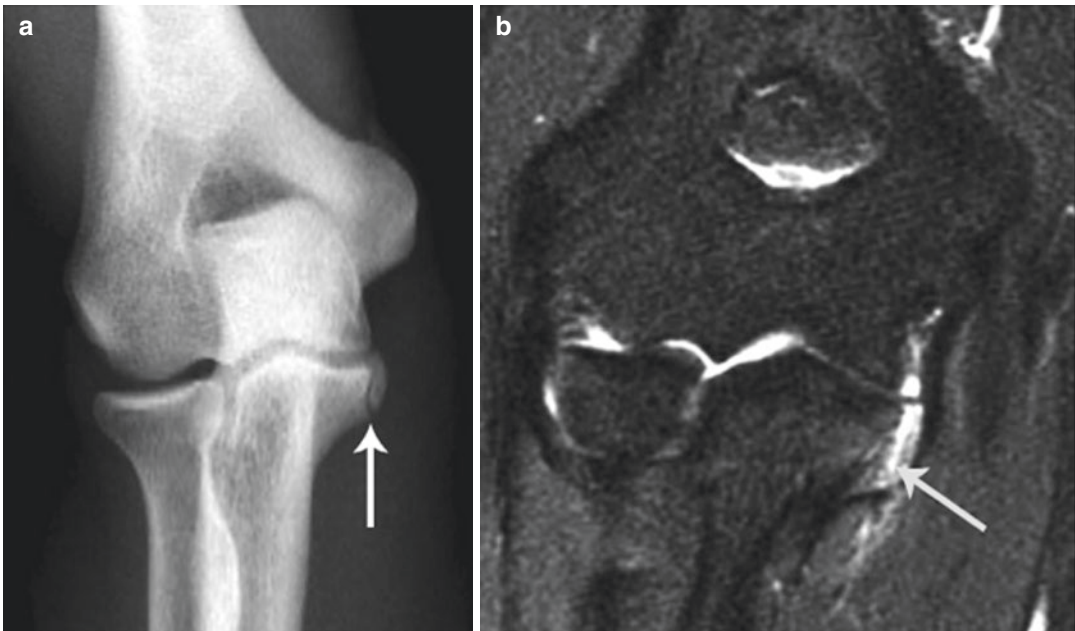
Plain film (a) and coronal STIR (b) demonstrate avulsion injury of the sublime tubercle (*arrows*)
